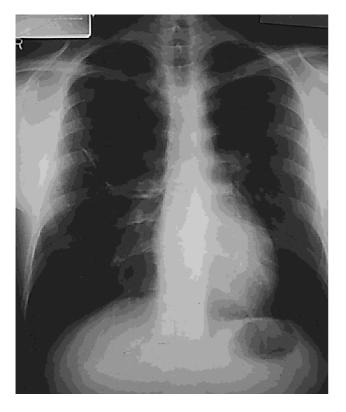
Chest radiograph (Case 3) showing large right pneumothorax with giant right upper lobe bulla containing fluid.
